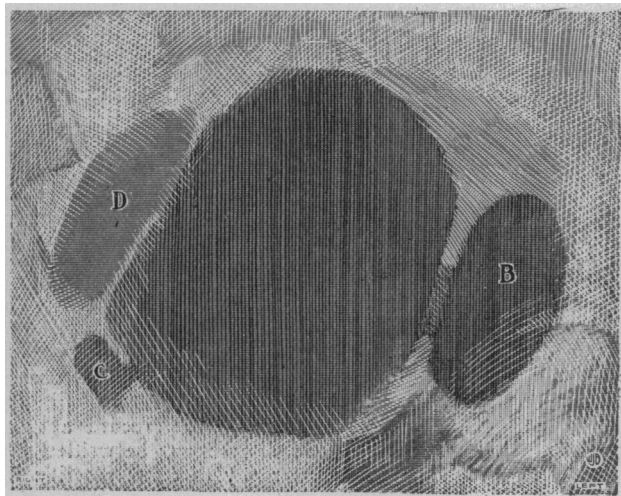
Diverticula (B, C, D) as shown by Roentgen ray (Case 5).
